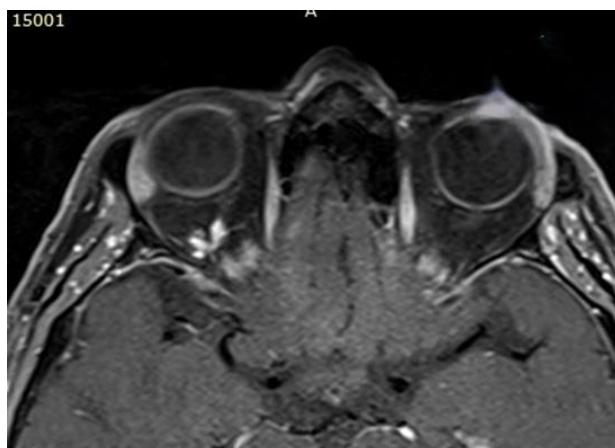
Fragment of magnetic resonance imaging of patient D., 65 years old.
